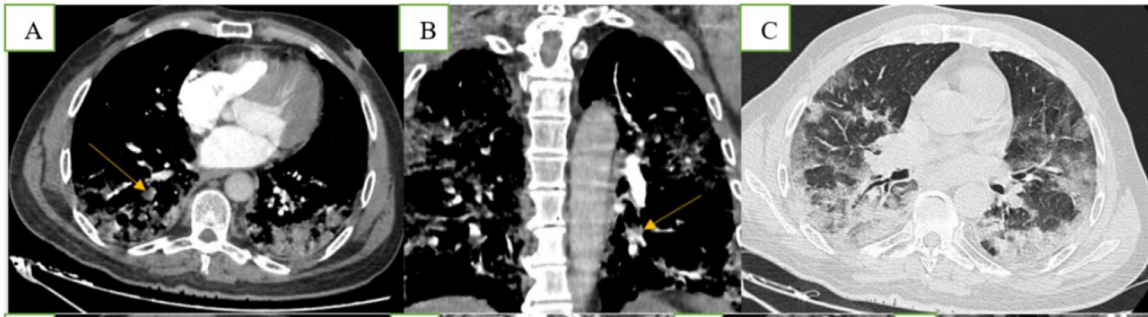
computed tomography pulmonary angiography (CTPA): (A) axial and (B) coronal reformatting (mediastinal windows) with a filling defect in the right segmental branch artery (yellow arrows), (C) axial reformatting (parenchymal window) showing typical patterns related to COVID-19-infection at the lung parenchyma including peripheral distribution of ground-glass opacities associated with consolidation.
